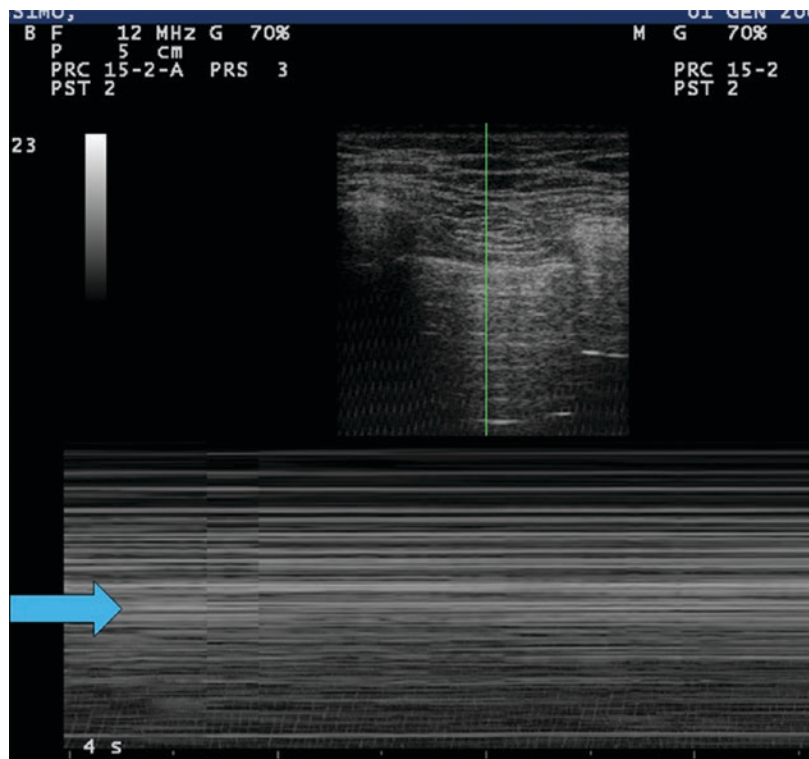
Moto-car crush: at lung ultrasound, with M-Mode, “stratosphere sign” and absence of pleural sliding suggestive of residual left anterior pneumothorax
